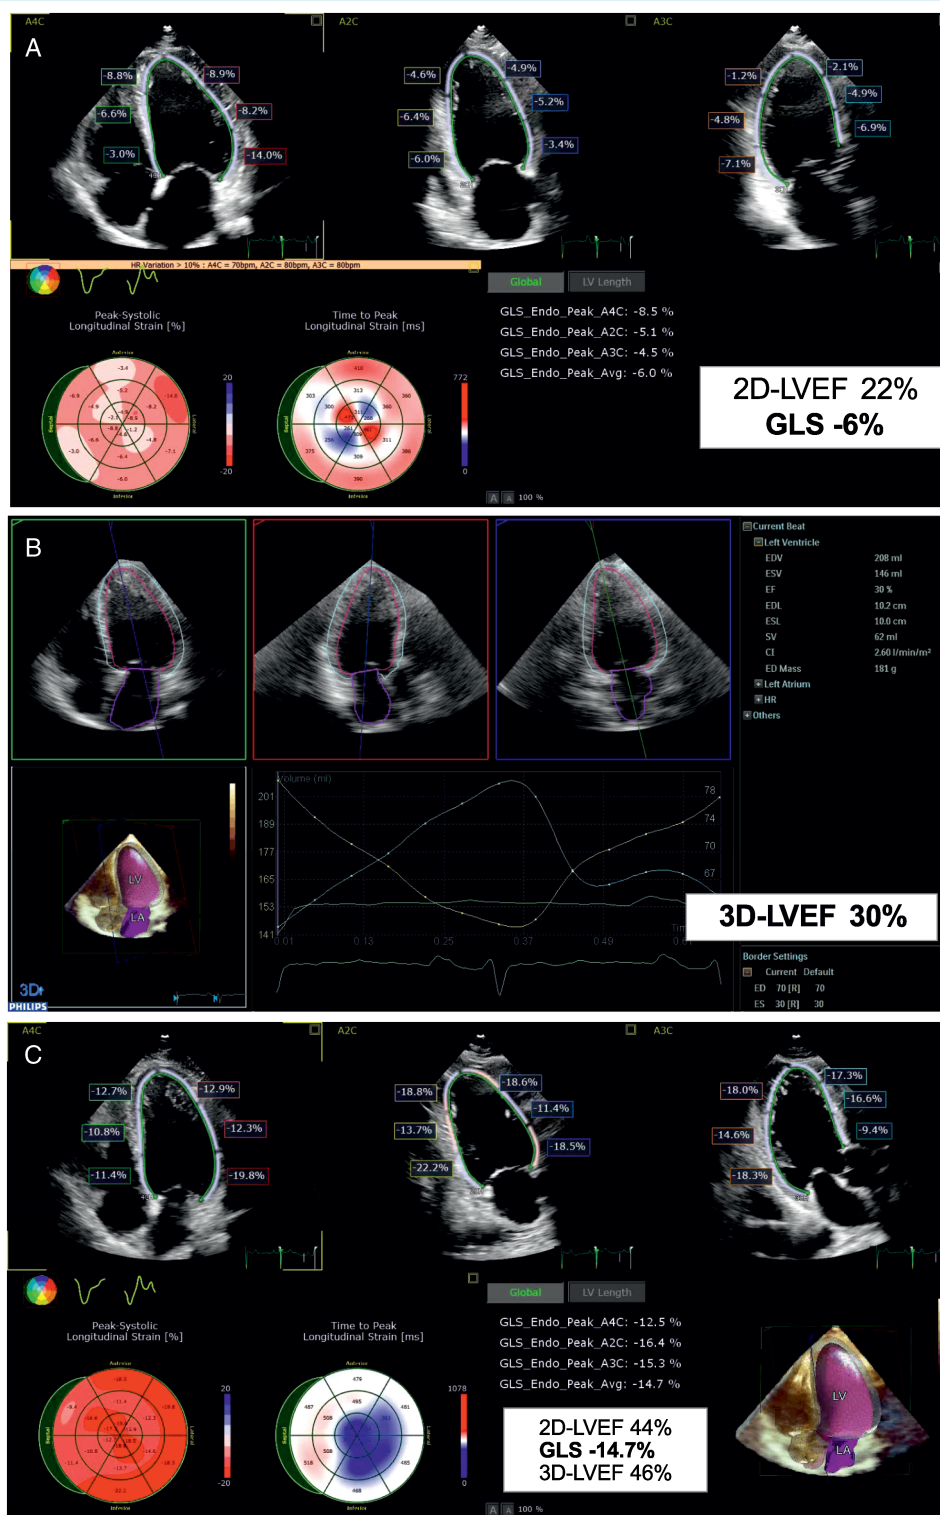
The case of a 44-year-old male in New York Heart Association functional class III. He had a history of Hodgkin's lymphoma at the age of 19 treated with doxorubicin, bleomycin, vinblastine, dacarbazine (ABVD) and mediastinal radiation. (A) Two-dimensional (2D) echocardiography with speckle tracking showed severe systolic dysfunction: low left ventricular ejection fraction (LVEF) and global longitudinal strain (GLS). Medical heart failure treatment (sacubitril/valsartan, bisoprolol, eplerenone, furosemide) and cardiac rehabilitation were administered. (B) Three-dimensional (3D) LVEF was equal to 30%. (C) After 6 months, a significant improvement of 2D, 3D LVEF and GLS is observed in parallel with a shift to New York Heart Association functional class I. LA, left atrium; LV, left ventricle.
